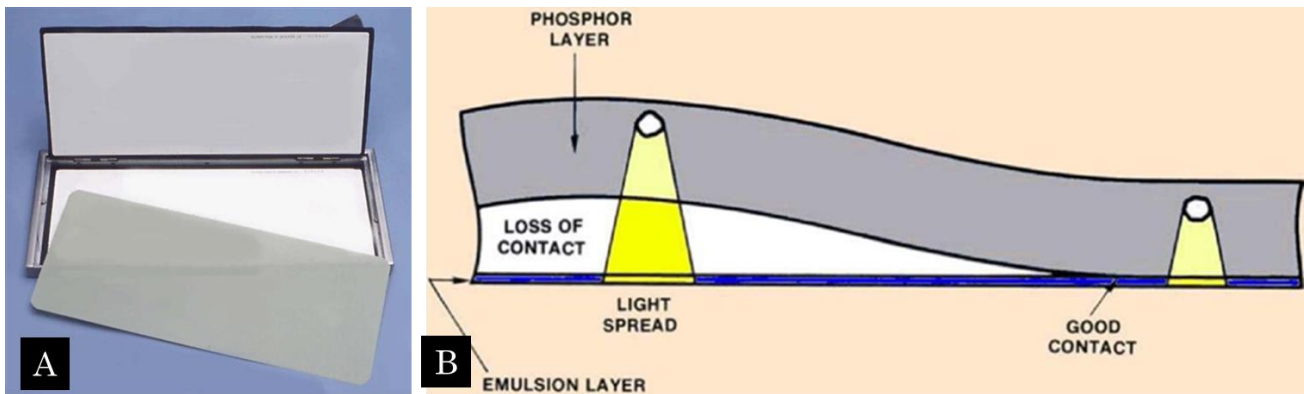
A, Cassette for 8 inch  $\times$  10 inch film along with a sheet of screen film. When the cassette is closed, the film is supported in close contact between the two white intensifying screens seen on the inside of the cassette. These intensifying screens absorb most of the incident x-ray beam and then fluoresce and expose the film. B, Poor and good film screen contact.
